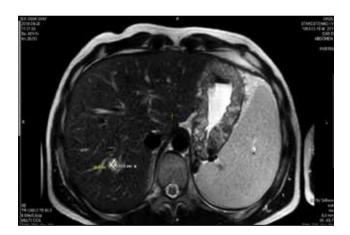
MRI of the abdominal organs. Visualization of a metastatic focus in the liver parenchyma
